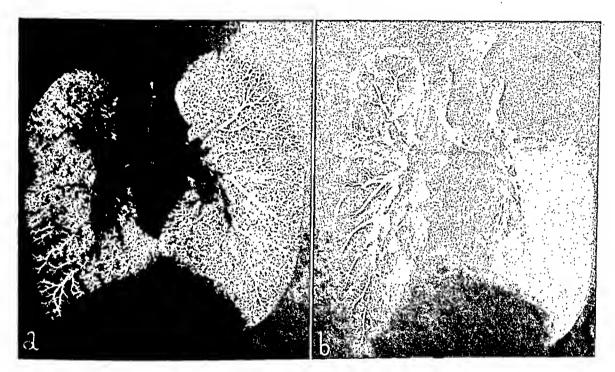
(Kindness of Drs. Birkelo and Brosius.) a, roentgenogram of excised normal lungs after injection of the vascular system with opaque material. Note the lacy pattern and the extensive ramifications of the small vessels at the pleural surfaces. b, roentgenogram of excised tuberculous lungs under similar conditions. Note the marked reduction in vascularity of the right lung in particular. It is thought that this degree of impairment of blood supply is an important factor in preventing healing of the disease.
